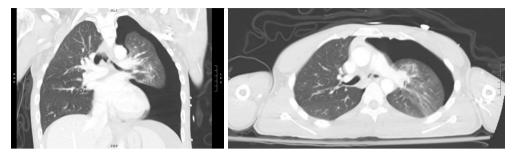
(CY7810 CT CAP from 10/10/2020). Curvilinear endoluminal filling defect within left mainstem bronchus with associated bronchial wall step-off, concerning for left mainstem bronchial injury. Moderate to large left-sided pneumothorax. CT, computed tomography; CAP, chest, abdomen and pelvis.
